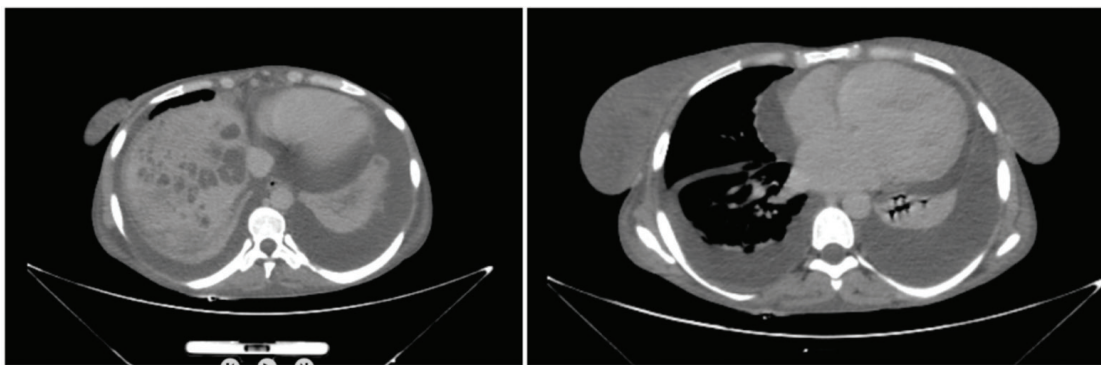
Before treatment CT images (bilateral pleural and pericardial effusions. Multiple hypodense abscess lesions in the liver)
